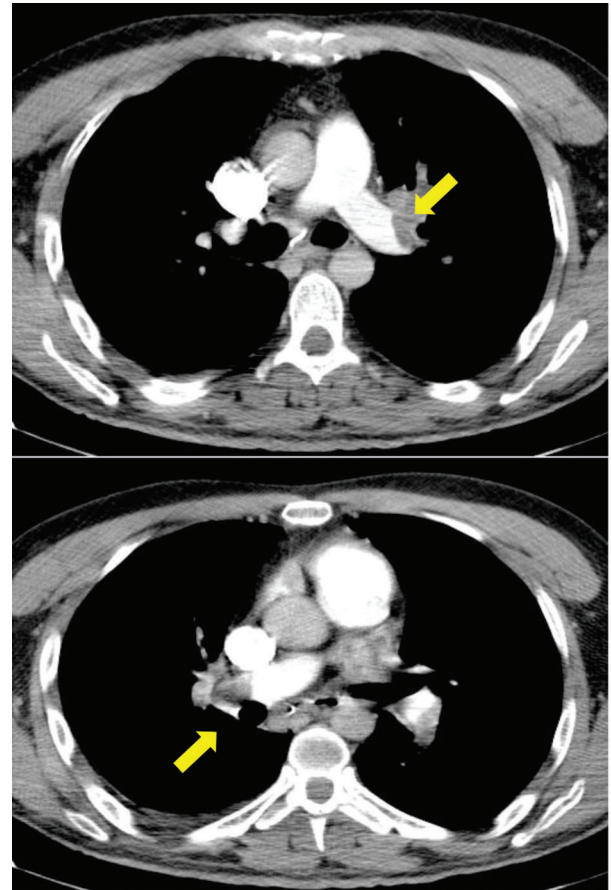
Pulmonary CT angiography showing thrombosis in pulmonary arteries (yellow arrows) and RV dilation (red arrows).
